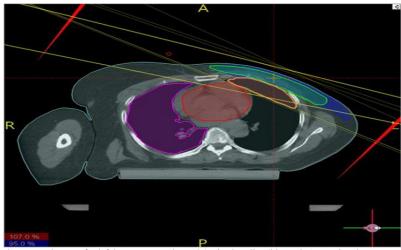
Computed tomography scan for left breast cancer shows 95% isodose line (blue color) covering the target volume (green color)
